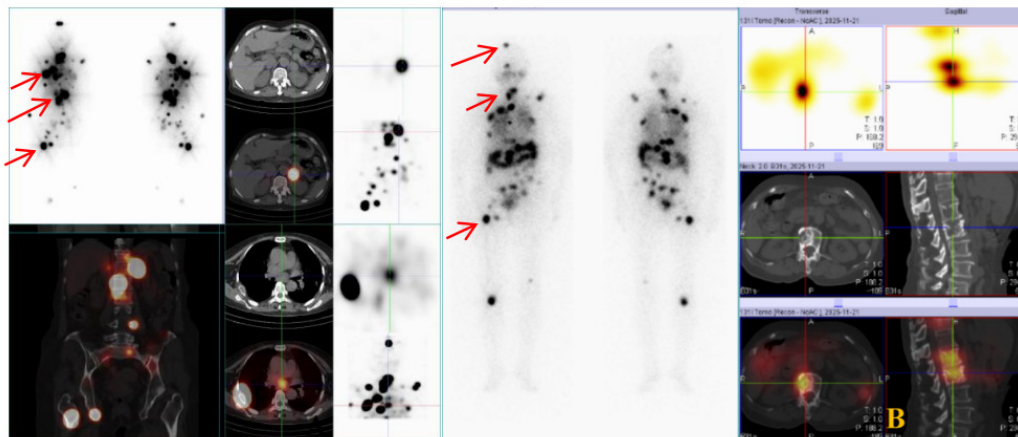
Whole-body iodine scintigraphy and SPECT/CT fusion images obtained on day 5 after each of the two courses of ^{131}I therapy (arrows indicate lesions). (A): Whole-body iodine scintigraphy and SPECT/CT fusion images after the first course of ^{131}I therapy. Multiple foci of increased radioactivity uptake are visible in the head, neck, thorax, abdomen, pelvis, and extremities. Multiple osteolytic destructive lesions with markedly increased radioactivity are seen in the frontal bone, spine, scapulae, ribs, pelvis, and extremity bones. (B): Whole-body iodine scintigraphy and SPECT/CT fusion images after the second course of ^{131}I therapy. Multiple foci of increased radioactivity uptake are still visible in the head, neck, thorax, abdomen, pelvis, and extremities. Compared with the previous iodine scan, the remnant thyroid tissue in the right thyroid lobe has decreased in volume and density, with reduced radioiodine uptake. The previously noted multiple bilateral pulmonary metastases, metastatic lymph nodes in the right supraclavicular region and right hilar region, as well as the adrenal metastasis, have markedly decreased in size, with no significant increase in radioactivity. The multiple osteolytic destructive lesions in the skull, spine, scapulae, ribs, pelvis, and extremity bones show predominantly osteoblastic repair changes on this scan. Some lesions show a slight size reduction, although increased radioactivity (indicating post-therapeutic repair changes) is still observed.
